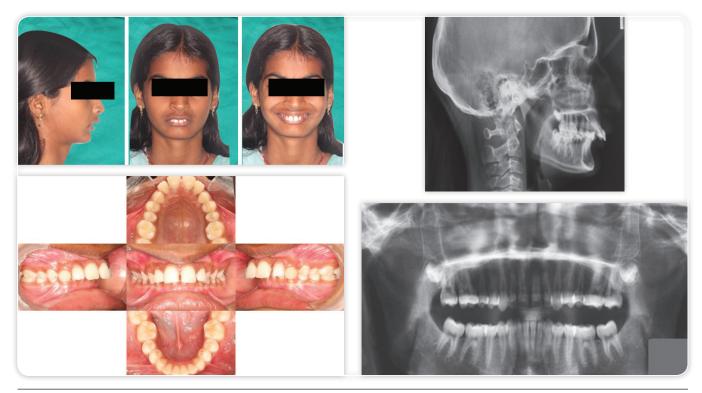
Pre treatment extra oral and intra oral photographs, lateral cephalogram and Orthopantomogram (Case 2)
